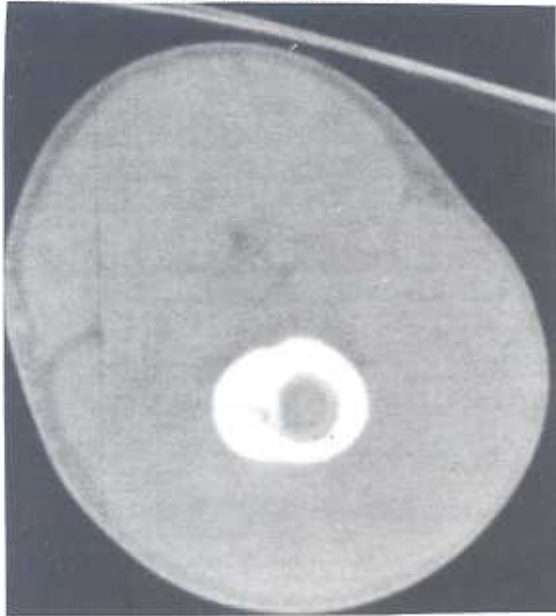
Osteoid osteoma 1/3 middle diaphysis of femur. CT section.
